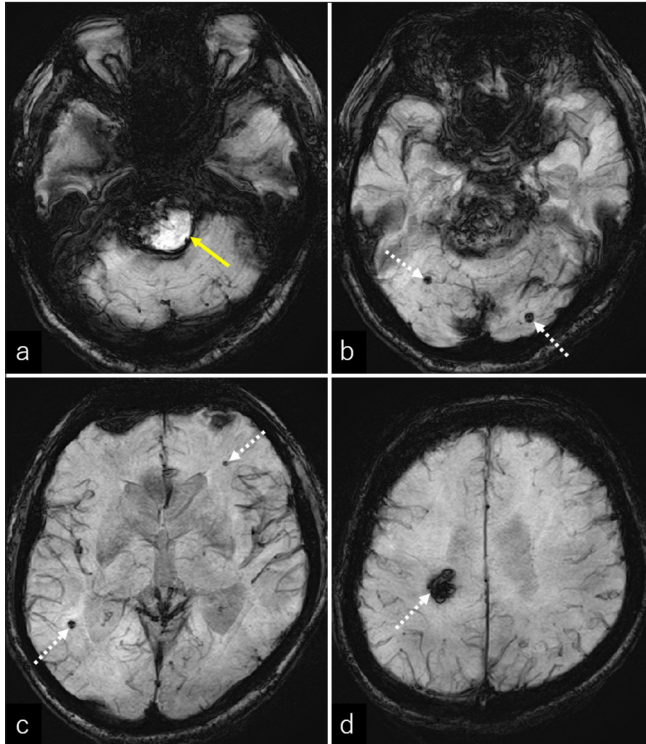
(a-d) Serial sections of axial susceptibility-weighted magnetic resonance imaging showing a hyperintense mass in the pons (a, arrow), in addition to multiple hypointense lesions suggesting hemosiderin depositions (b-d, dashed arrow).
